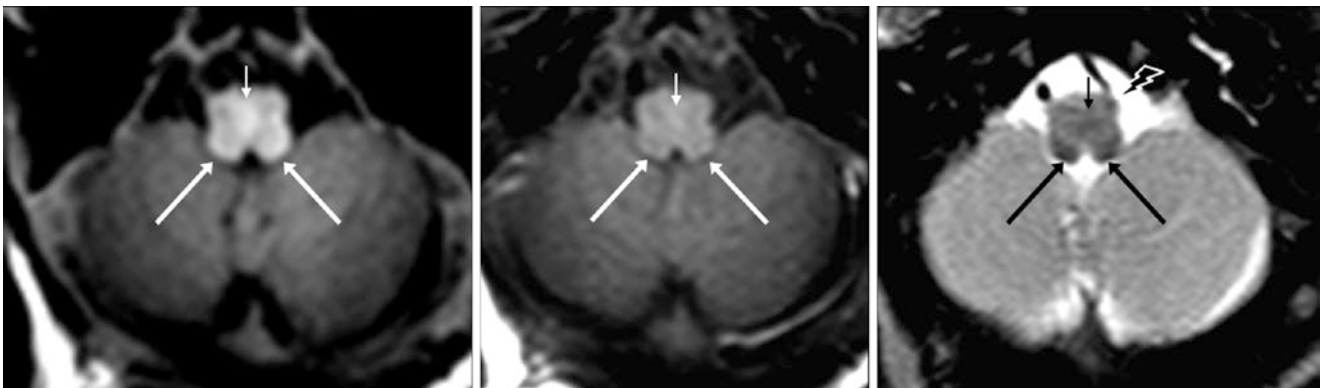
A 7-day-old term neonate had a normal 3T MRI, including spoiled GE T1WI (*left*), SE T1WI (*middle*) and SE T2WI (*right*). Note the mildly T1-bright and T2-dark PD (*tiny arrows*) and inferior
